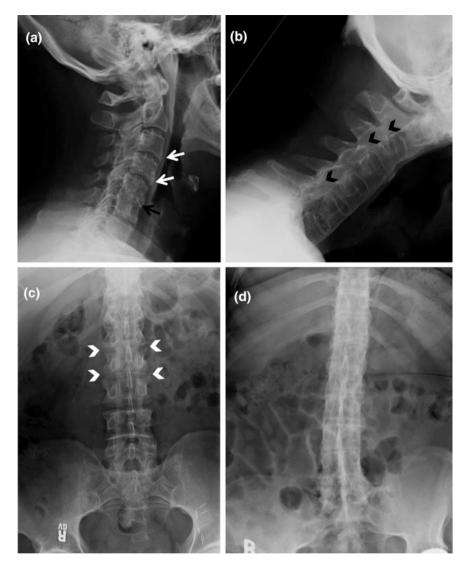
Plain radiographs of the spine in patients with ankylosing spondylitis. a Lateral view of cervical spine. Syndesmophytes (*white arrows*) that projected vertically from the edge of the vertebral body. There is loss of intervertebral disk space (*black arrow*). b Lateral view of a completely fused cervical spine. Notice the 'bamboo' shape of vertebral column and complete loss of facet joints (*black arrowheads*). c Anteroposterior view of lumbar spine showing syndesmophytes (*white arrowheads*), some of which are almost bridging. d Anteroposterior view of a completely fused lumbar spine (*bamboo spine*). The linear vertical density in the center of the spine is formed by calcification of the ligaments between adjacent spinous processes
